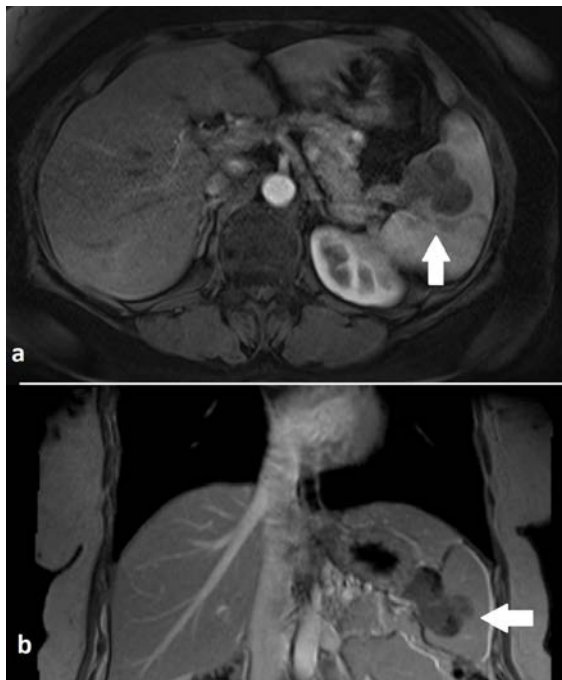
Contrast-enhanced T-1 weighted magnetic resonance imaging of the abdomen with the arrow indicating the splenic tumor: a – axial slice, arterial phase; b – coronal slice, delayed phase.
